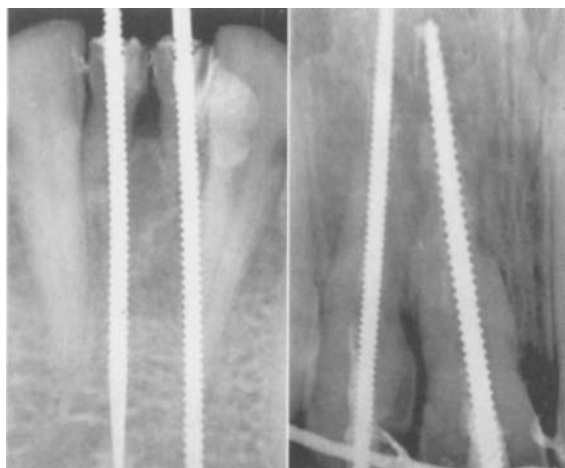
■ Periapical radiographs of successful endodontic stabilization.
